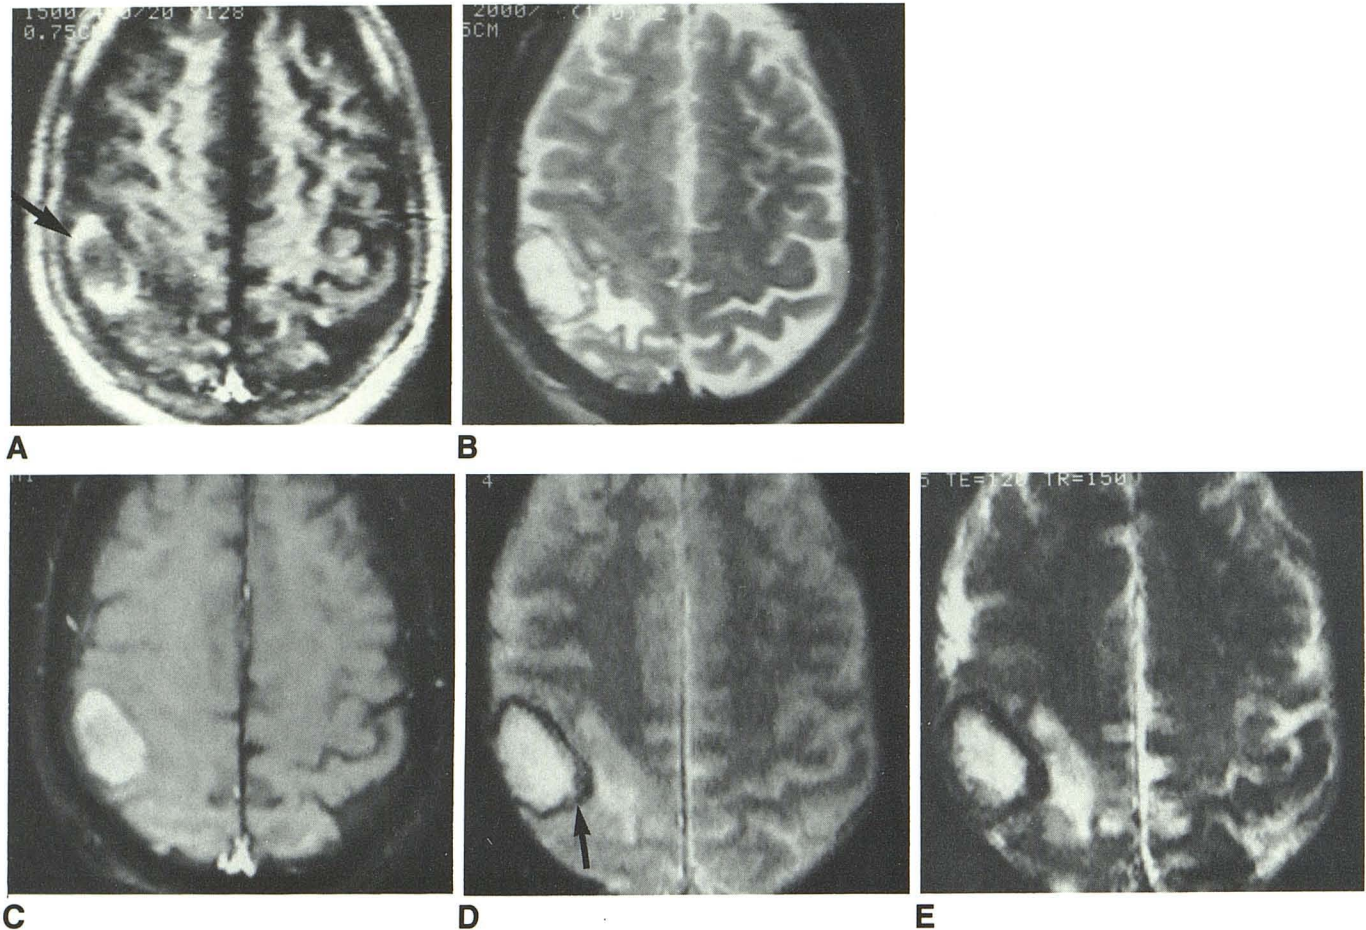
Patient with 4-week-old right parietal hemorrhage. A, T1-weighted IR image shows hyperintense ring (*arrow*), presumably due to paramagnetic methemoglobin. B, Heavily T2-weighted SE image (TE = 120 msec) shows no definite evidence of a magnetic susceptibility effect. C, T1-weighted PS image (TE = 16 msec) shows marked hyperintensity of lesion. Again note prominent
